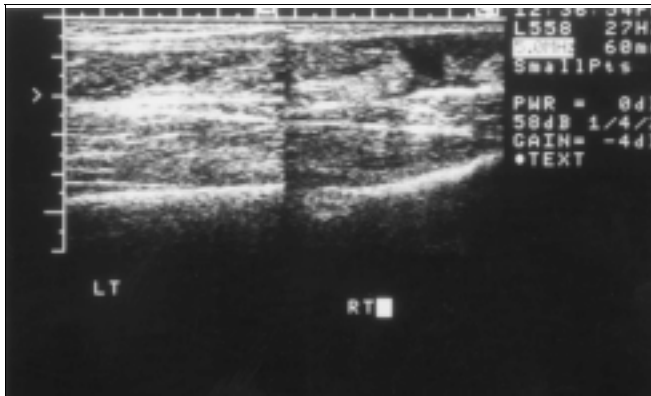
Longitudinal sonogram of normal Achilles tendon (left) and a complete tear of the Achilles tendon (right).
